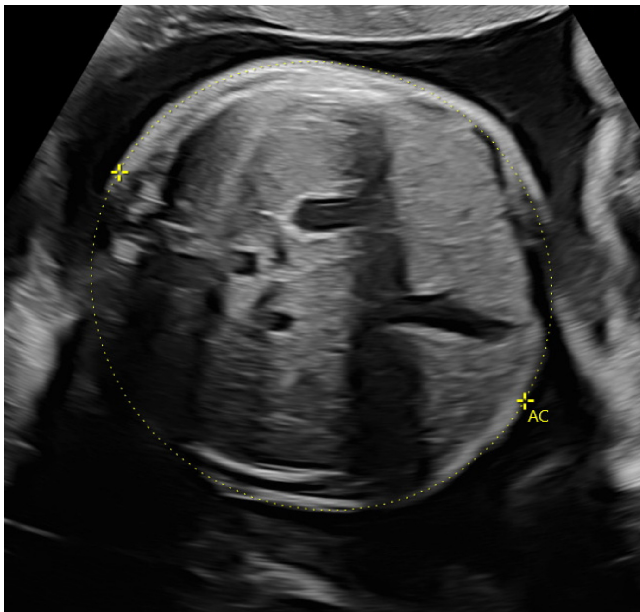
Sonographic measurement of fetal abdominal circumference (AC) in third trimester.
